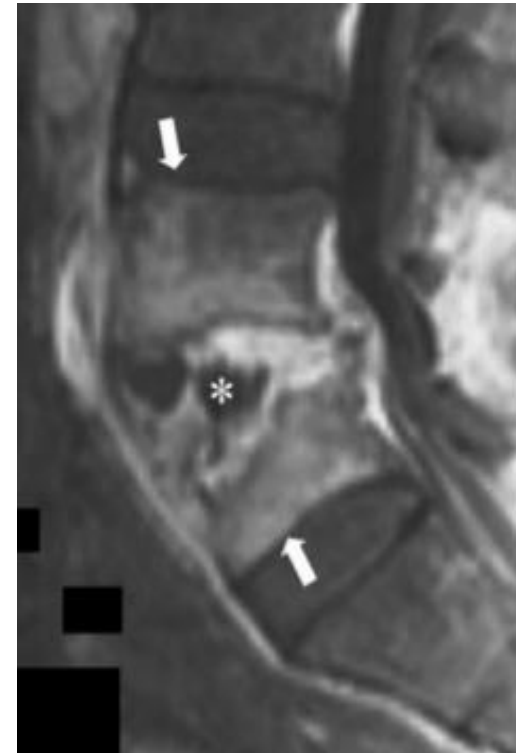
Sagittal T1+C MR image in pyogenic abscess shows irregular enhancement of abscess (asterisk) presents in L4-5 disk space extending to L5 vertebral body.
